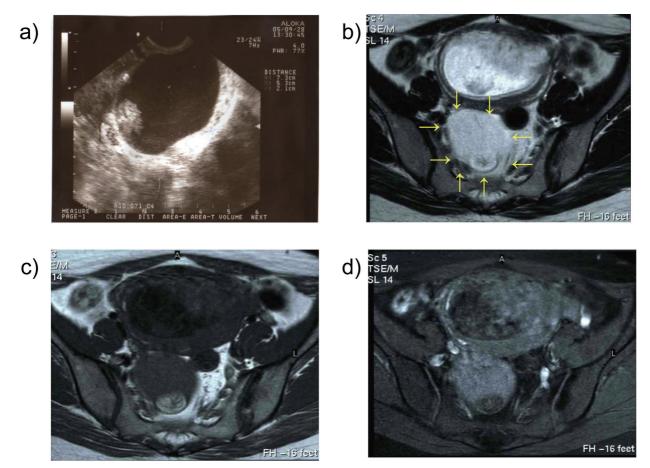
Shows USG and MRI findings of case 9. a) USG, b) MRI T2WI, axial, c) MRI, T1WI axial, d) MRI, T1WI fat saturation, axial.
